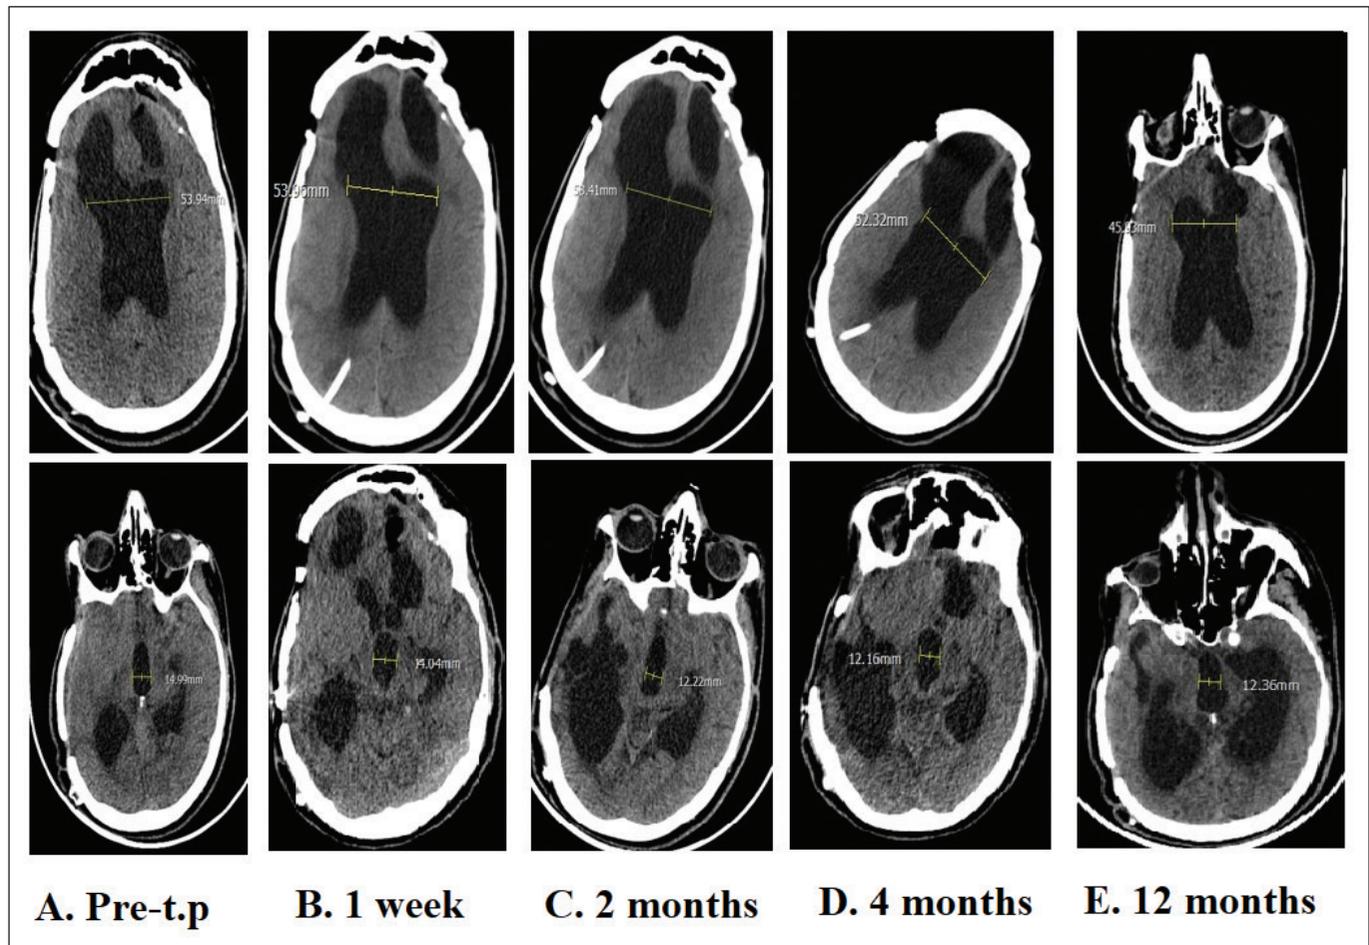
The former postoperative cranial CT demonstrated encephalomalacic sequelae and hydrocephalus with VP shunting (A). Repeated cranial CTs on the first week (B), second month (C), third month (D), and 12th month (E) after the first intervention.
